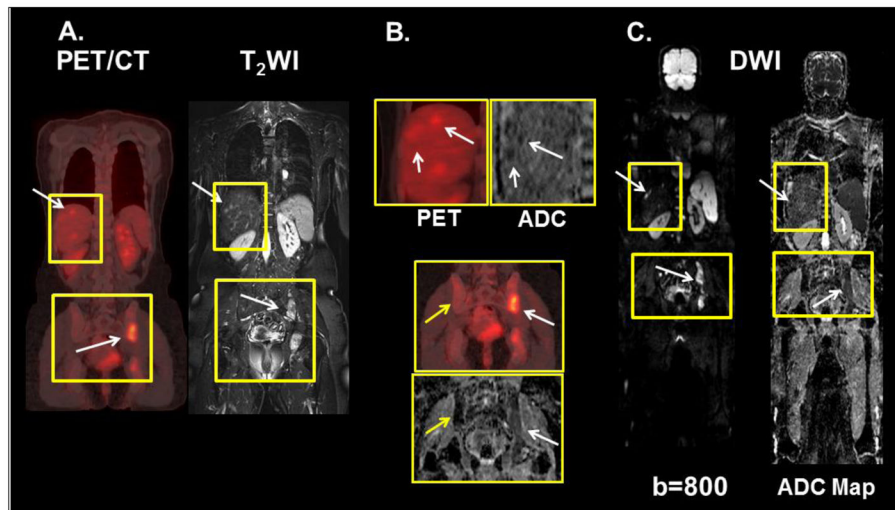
Demonstration of the WB-MRI and PET/CT in a 46-year-old woman with metastatic breast cancer in the liver and pelvis. A.) The white arrows in liver and pelvis show metastatic lesions on PET and T₂-weighted images. B.) The PET and ADC maps demonstrate the metastatic lesions (white arrows) in the liver. In the pelvis, the yellow arrows indicate normal bone on the ADC map and PET. The white arrows show the metastatic lesions. C.) The same metastatic sites are noted on the WB-MRI diffusion-weighted images (b=800) and the ADC map.
